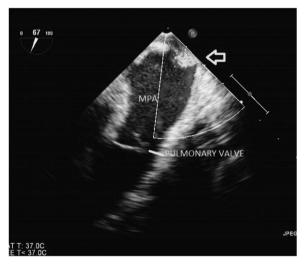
Transoesophageal echocardiography image showing abnormal flow into the PA at the level of PA bifurcation. MPA = main pulmonary artery; PA = pulmonary artery.
